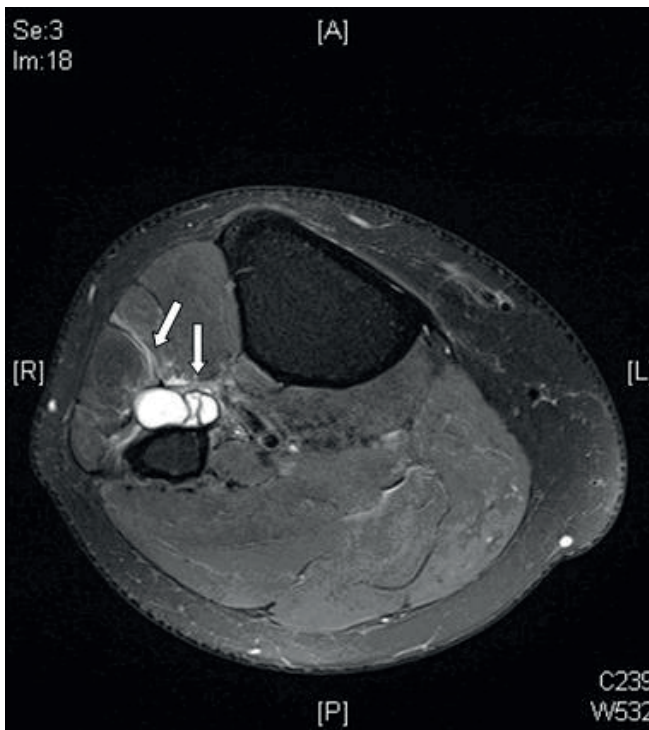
T2-weighted axial magnetic resonance image showing slight hyperintensity of the anterolateral muscle compartment compatible with denervation.(arrows)
